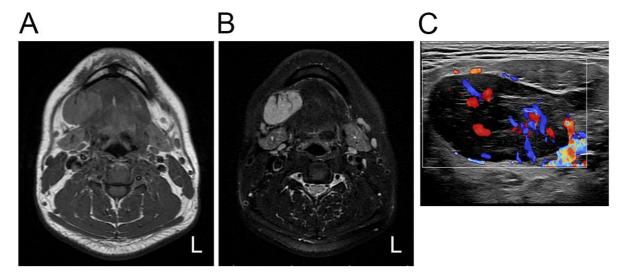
The MRI results reveals an elliptical abnormal signal located in the right submandibular region, with isointensity on T1WI (A) and hyperintensity on T2WI (B). C Color ultrasonography reveals abundant blood flow signals in the mass L: Left. Image reused from Wang C, Wang B, He J. Solitary fibrous tumors of the oral and maxillofacial region: a case series from a single-center. BMC Oral Health. 2024 Nov 27; 24(1):1444. Available from https://bmcoralhealth.biomedcentral.com/articles/10.1186/s12903-024-05241-2
